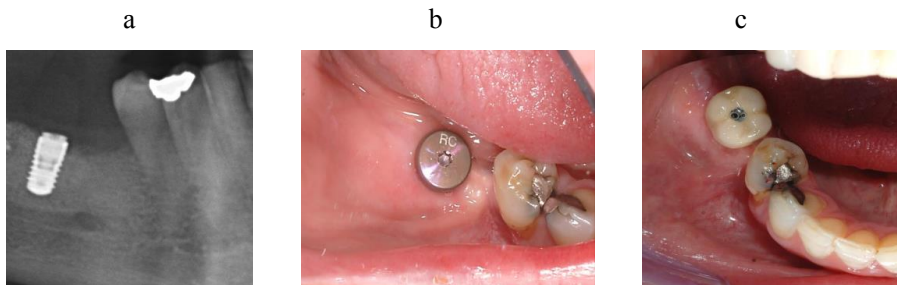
(a) X-ray before abutment surgery, (b) Clinical picture after abutment installation, (c) Clinical picture after crown installation.
